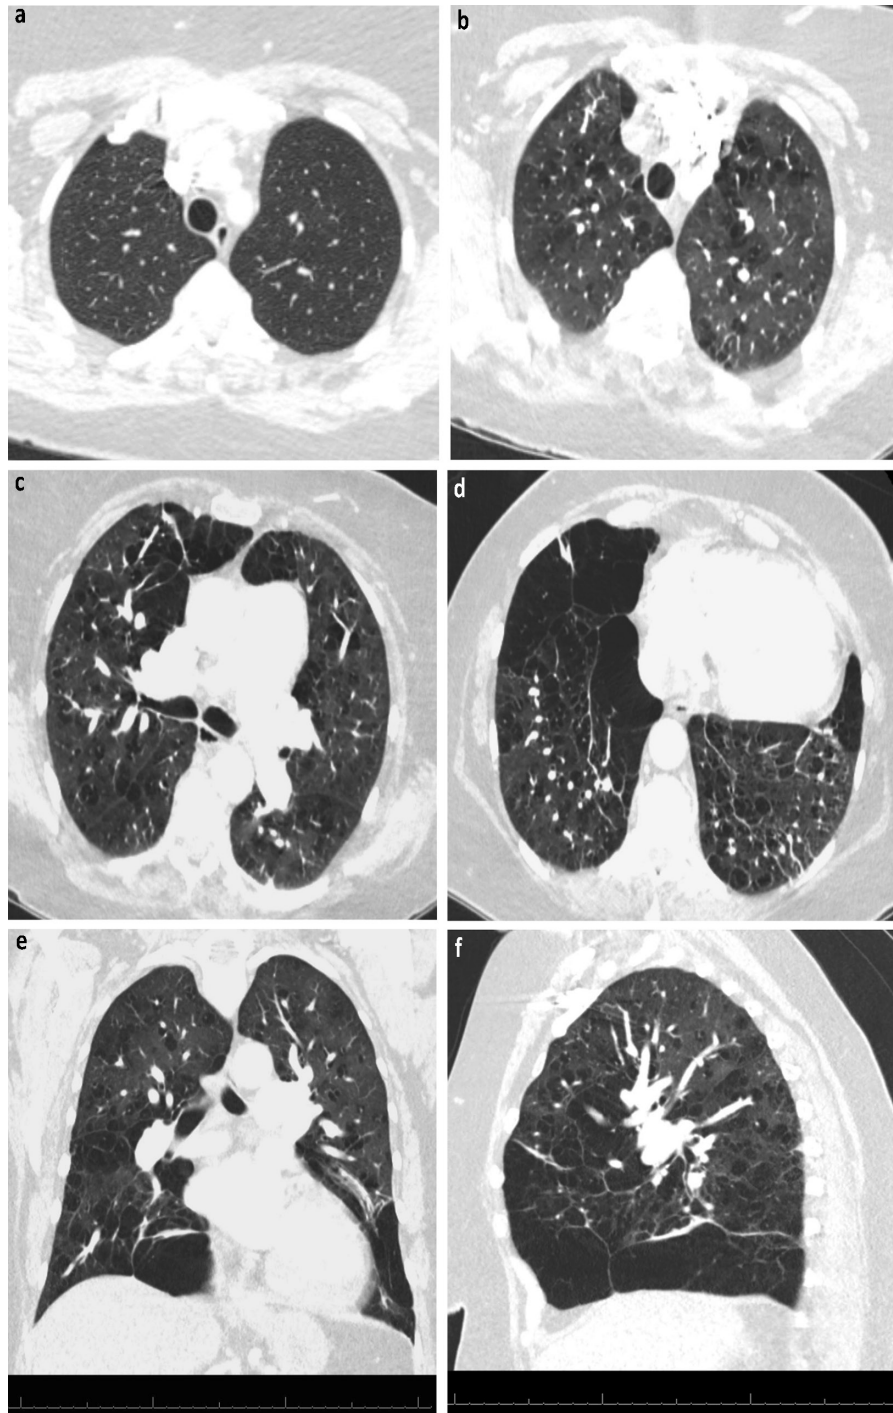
Computed tomography. a) Axial plane from 2008. b, c and d) Axial plane from 2020. e) Coronal plane from 2020. f) Sagittal plane from 2020.
